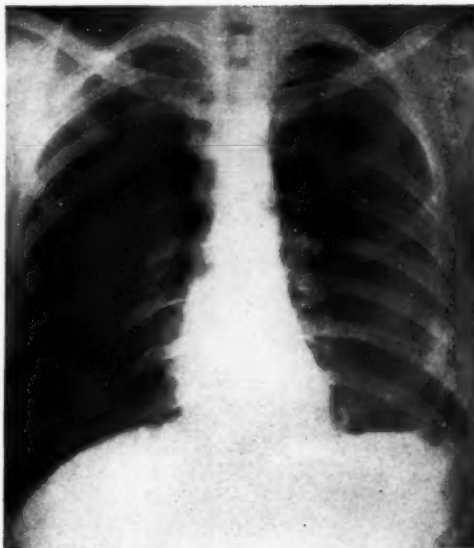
Roentgenogram of chest after surgery.
